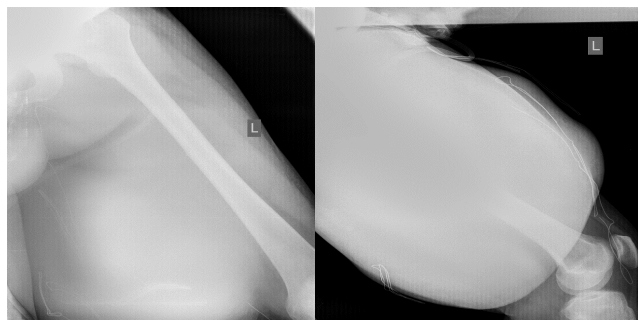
Left thigh X-rays: Inhomogenous soft tissue enlargement with no bone lesion.
